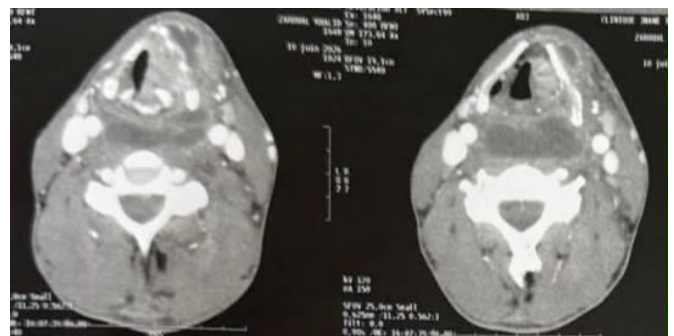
CT scan images (axial view) showing a large hypodense retropharyngeal collection associated with a locally advanced laryngeal mass centered on the left vocal cord with thyroid cartilage invasion.
